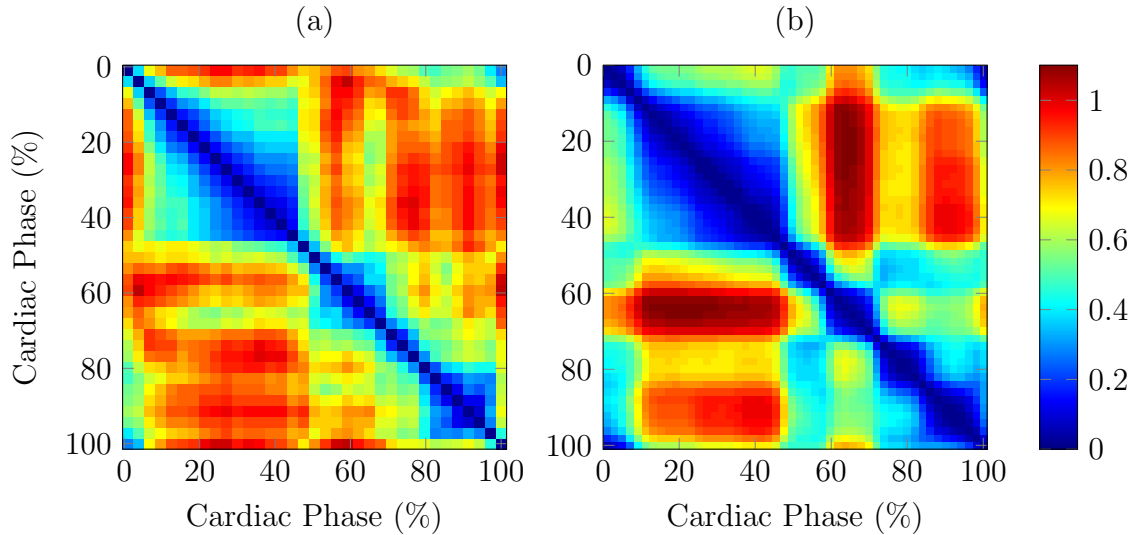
Comparison of deviation matrices from echocardiography (a) and CT (b).
